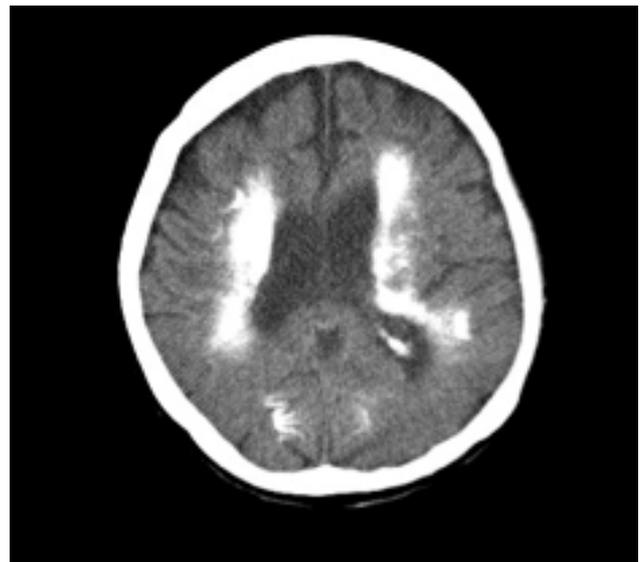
Computed tomography sign of Fahr's Syndrome
